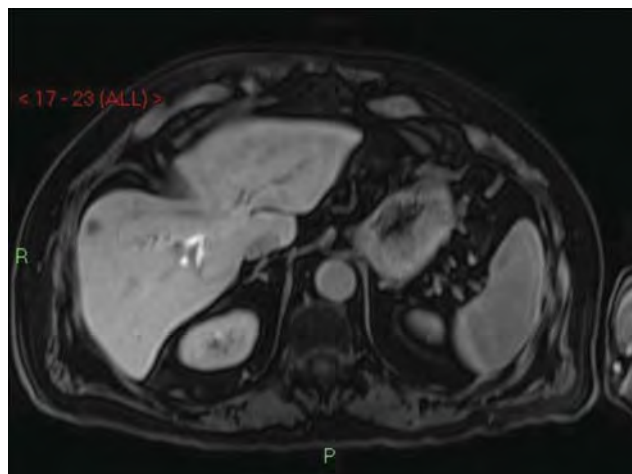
One of multiple lesions seen on MRI consistent with multiple liver metastases (subcapsular location, segment VIII). Follow-up CT 4 months later demonstrated increase in the number and size of liver metastases.
